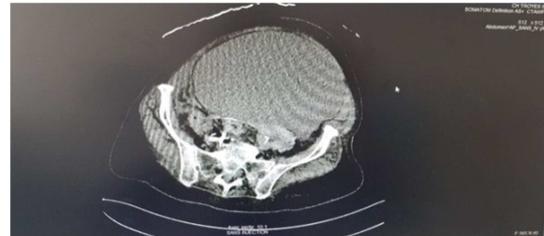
CT scan showing giant fecal impaction.
